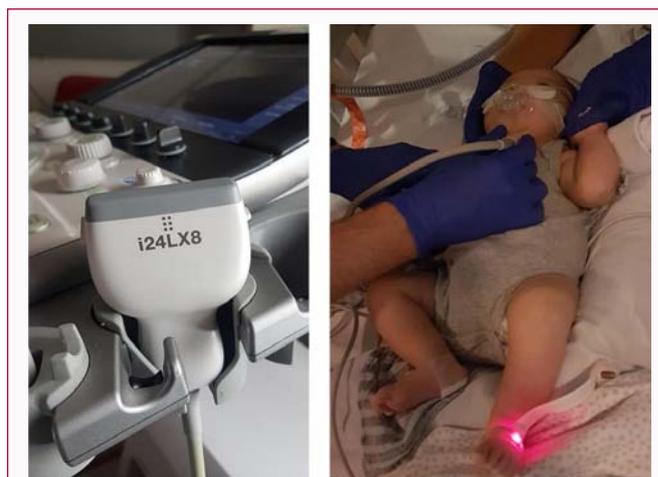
Bedside capture of vocal fold mobility using ultrasound.
